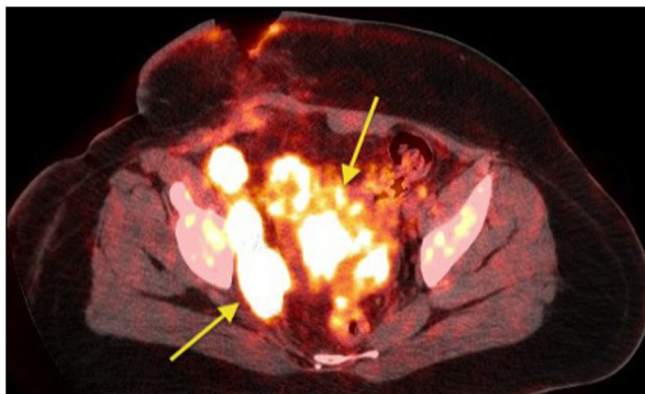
PET/CT image demonstrating foci of hypermetabolism within the postoperative bed and the right pelvic sidewall (arrows).
